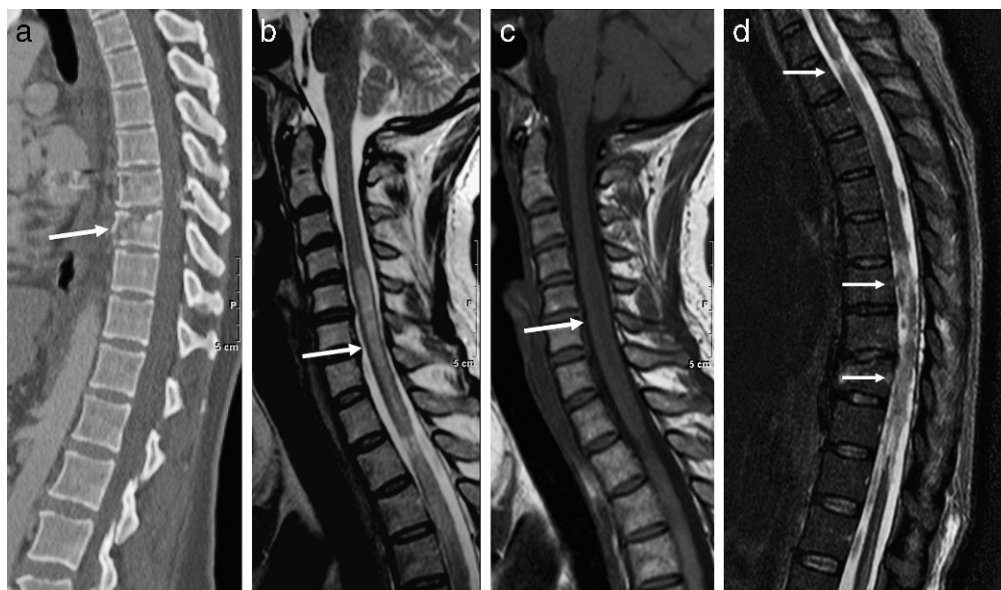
PPMM. (a) Sagittal CT demonstrates a gunshot wound through the spinal canal at the T8–T9 level (arrow). (b) Sagittal T2-weighted image a few months later demonstrates abnormal signal (arrow) much higher in the cord compared with the primary injury. (c) On the sagittal T1-weighted image, the lesion is slightly hypointense to the cord (arrow). Note that the signal intensity of the lesion is more consistent with edema than cyst formation. (d) The sagittal STIR demonstrates cord signal abnormality at the level of the injury extending cranially (arrows).
